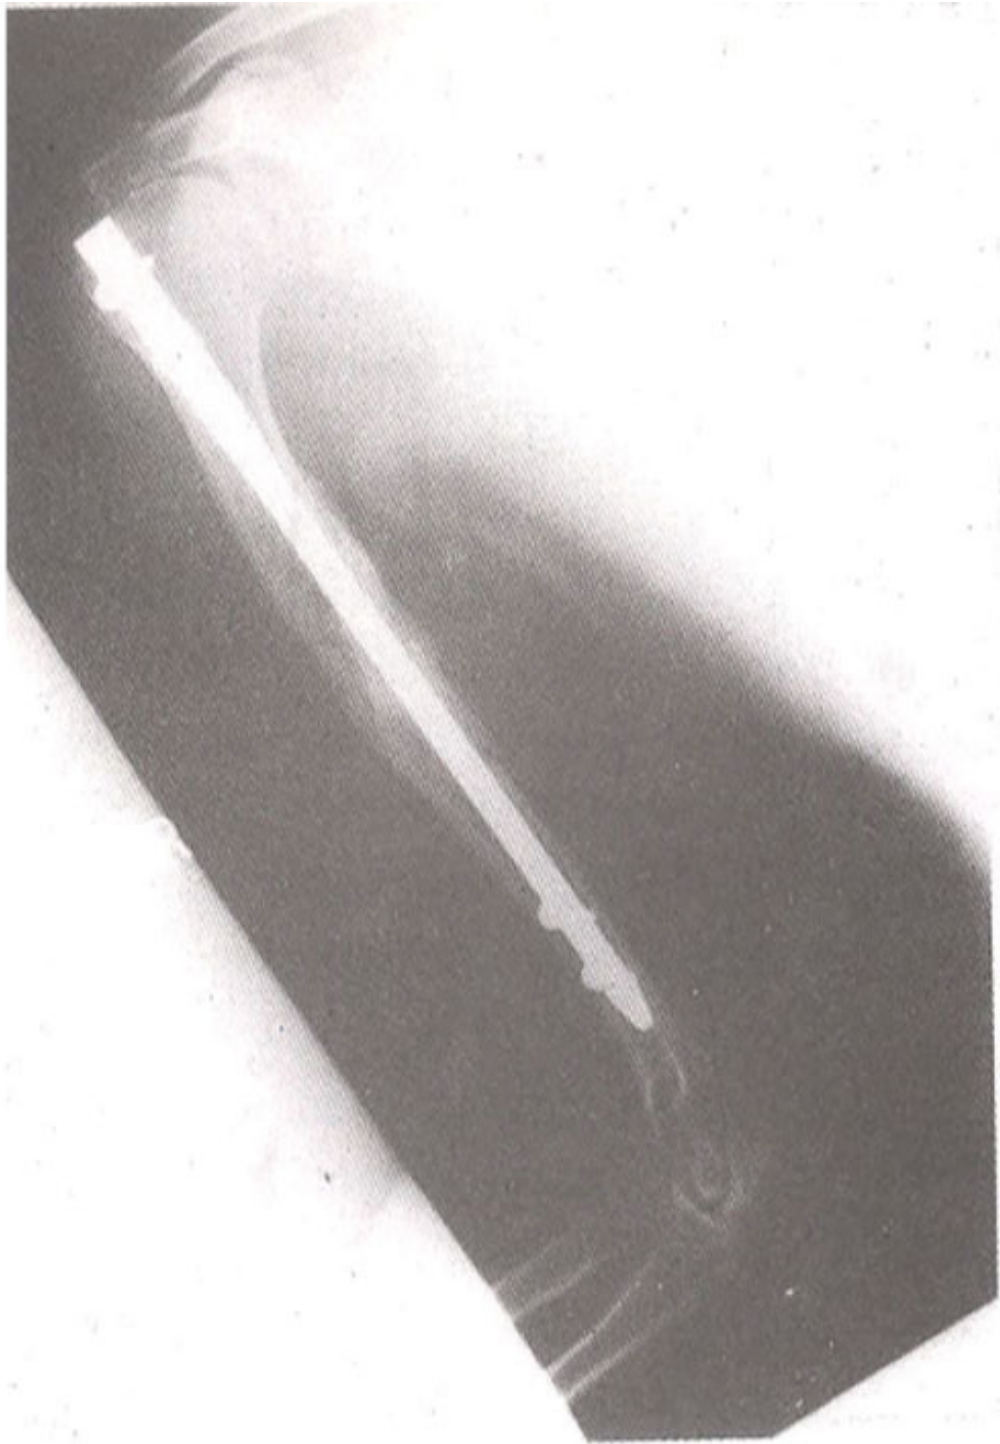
X-ray at three years showing consolidated fracture. The patient has a full range of motion at the shoulder (i and ii).
